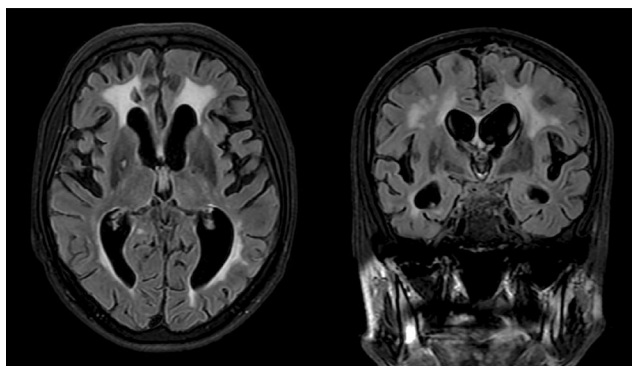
Brain MRI severe brain atrophy, mainly hippocampus and temporal lobes. Also hydrocephalus of chronic characteristics, with confluent T2 hyperintensity affecting the periventricular white matter, related to demyelination of probable chronic hypoxic origin
